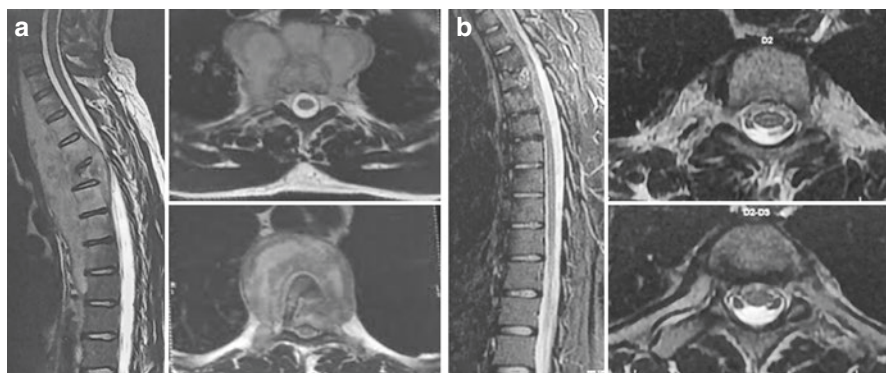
(a) Pre-treatment MRI T2-T3 TB spondylodiscitis with a large prevertebral, epidural abscess, vertebral edema, and destruction. (b) MRI images after 9 months of multidrug-anti-tubercular therapy show a significant reduction in vertebral edema and complete resolution of abscess, suggesting good healing response
